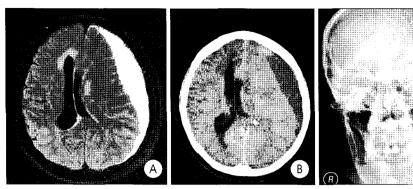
A, B: Initial magnetic resonance and computerized tomographic images showing chronic subdural hematoma. C: Postoperative plain skull X-ray showing small craniotomy and an indwelling catheter in the subdural space.
